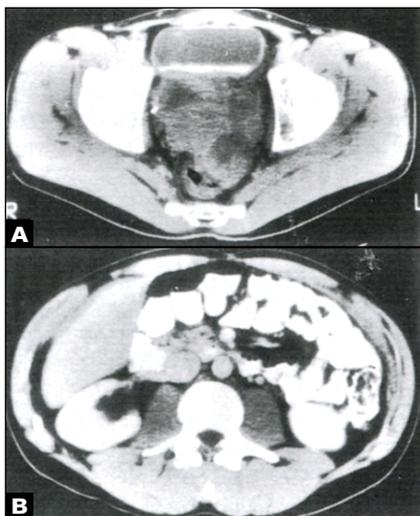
Radiographic appearance of rhabdomyosarcoma. (A) Large tumor arising from the bladder-prostate region. This patient presented with obstipation and a palpable mass on rectal exam. (B) These tumors can grow quite large before they are diagnosed, often leading to obstruction of the ureters and hydronephrosis (seen in the right kidney). Cystectomy or pelvic exenteration is rarely indicated in the primary management of these tumors.
